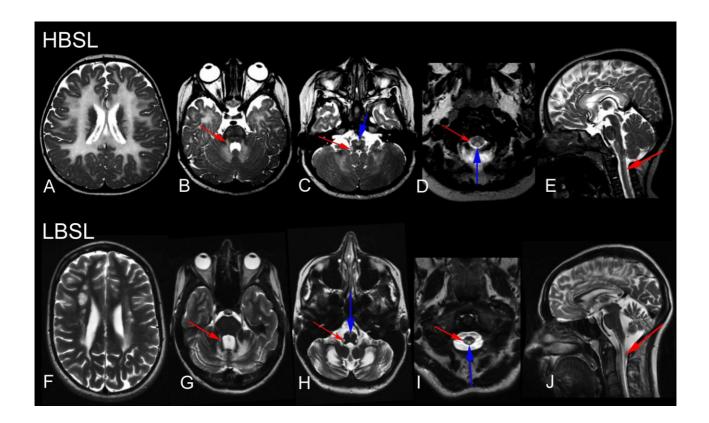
A Comparison of HBSL and LBSL MRI Patterns
